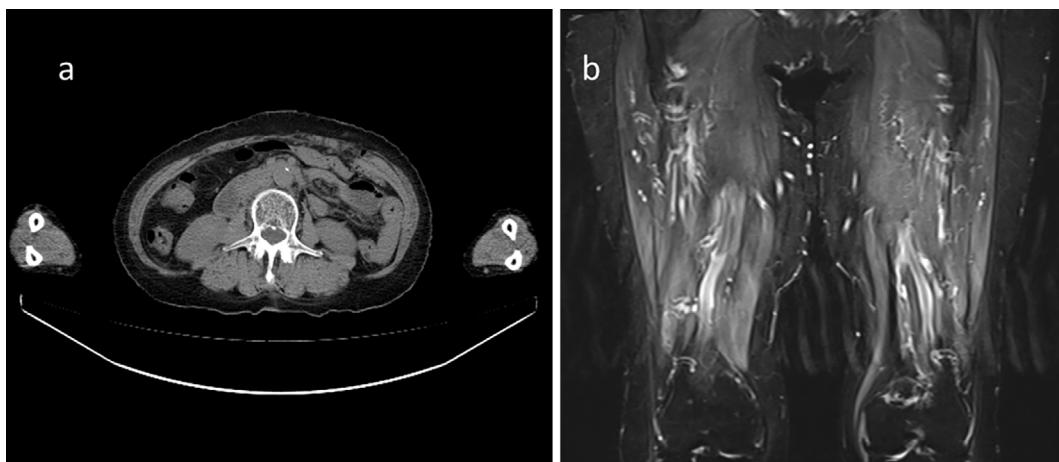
The imaging findings. Plain CT in 2017 revealed symmetric atrophy of both forearms (a). MRI revealed symmetrical heterogeneous areas of high signal intensity in both thighs on T2-STIR sequences (b).
